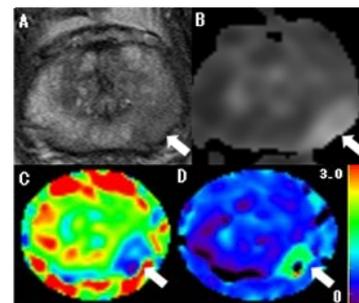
A 73-year-old man (PSA level, 12.1 ng/mL) with PC (solid arrows). A: T2-weighted image, B: ADC-map, C: D-map, D: K-map. Compared to healthy tissue, tissue with PC showed higher K and lower ADC and D .
